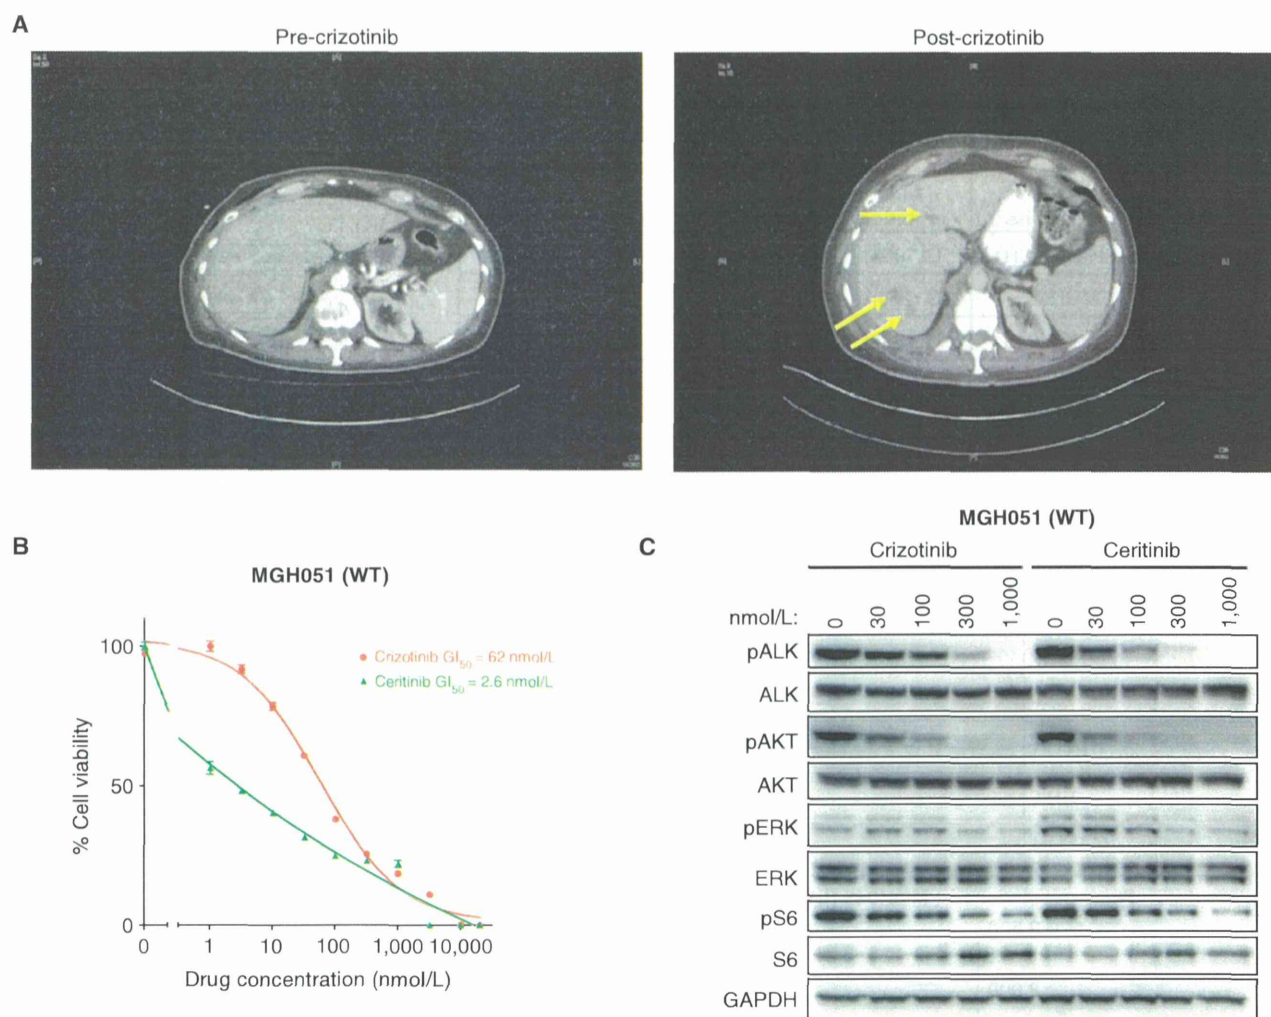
Ceritinib is active in *ALK* wild-type (WT) crizotinib-resistant cell line. A, abdominal computed tomography (CT) images of patient MGH051 before treatment with crizotinib and after 11 weeks of crizotinib. Several new hepatic metastases (yellow arrows) were detectable after crizotinib treatment consistent with disease progression. A repeat biopsy of a hepatic metastasis was performed within 2 weeks of crizotinib discontinuation. B, MGH051 cells were treated with the indicated doses of crizotinib or ceritinib for 7 days. After the incubation, the cell survival was assayed by CellTiter-Glo. C, MGH051 cells were treated with the indicated concentrations of crizotinib or ceritinib for 24 hours. Lysates were probed with antibodies directed against the indicated proteins.
